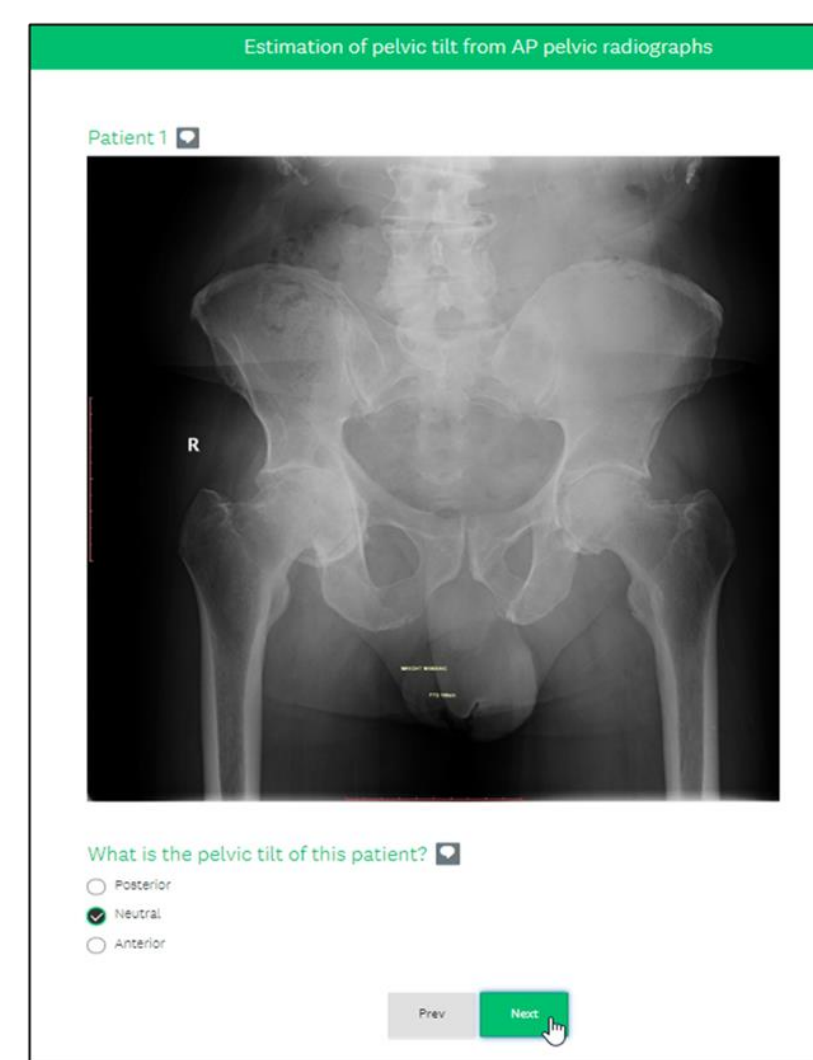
Sample of AP radiograph used to query surgeon ability to predict pelvic tilt
